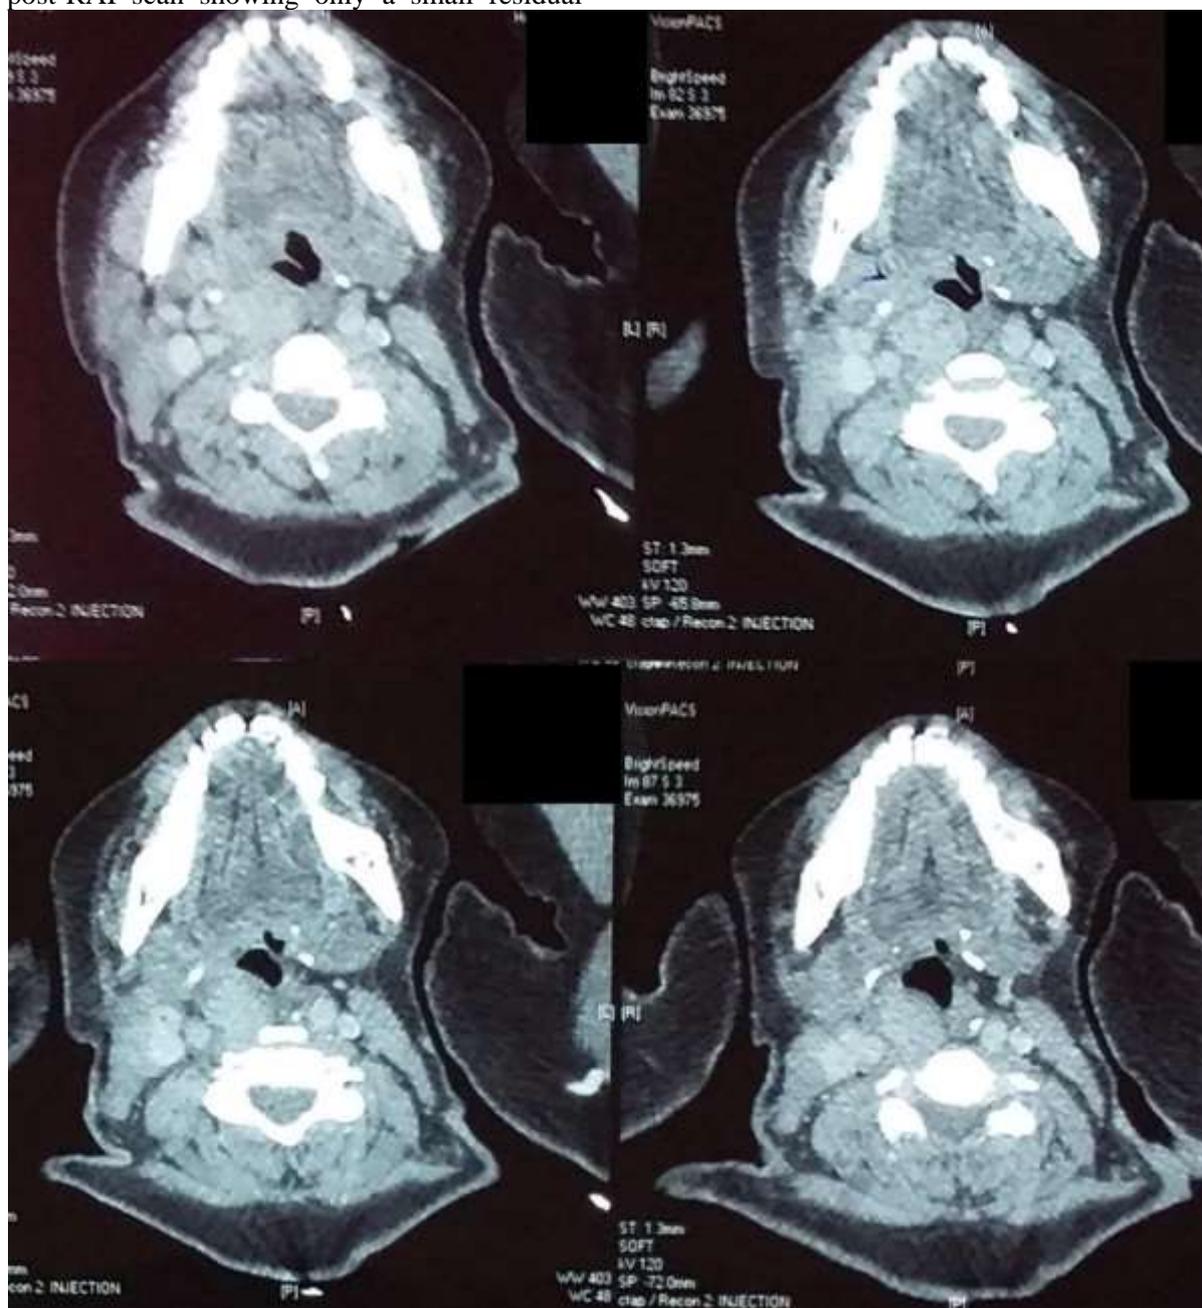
CT scans showing retropharyngeal lymph node metastases in the patient.
